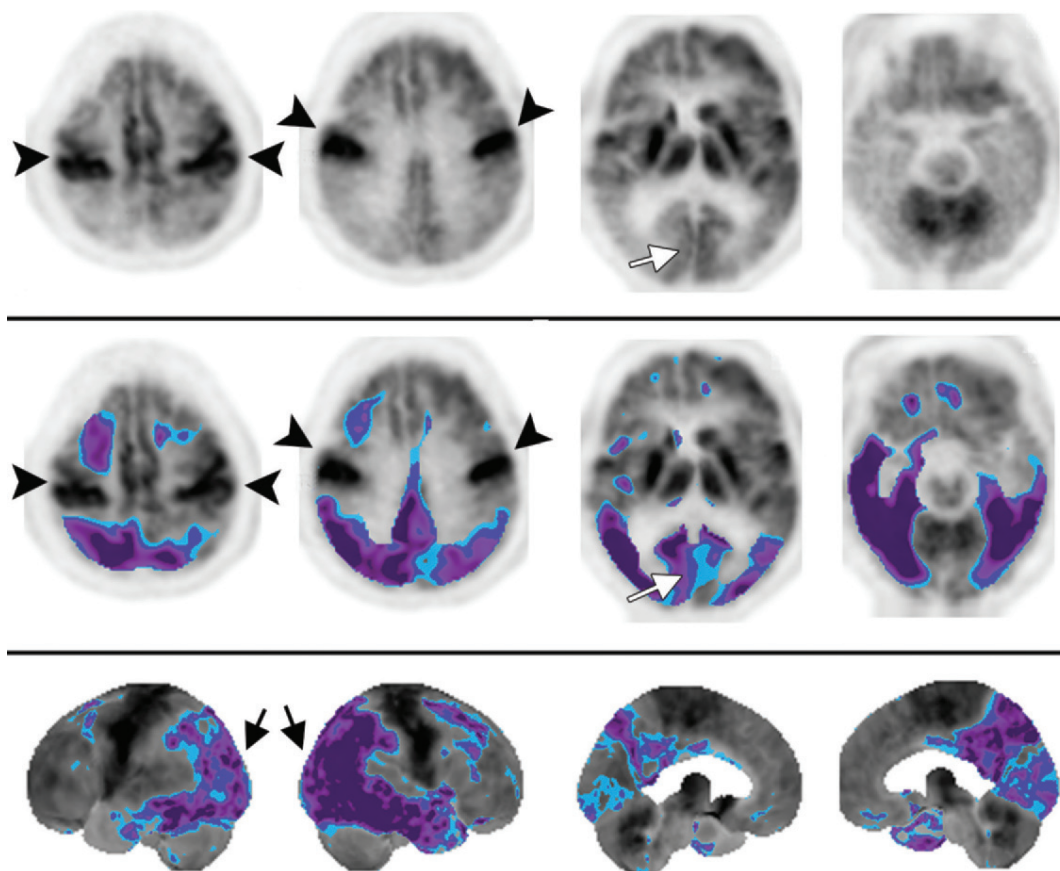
DLB. Axial gray-scale FDG PET images (top), corresponding statistical thresholding overlay images (middle), and 3D SSP images (bottom) (left to right: left lateral, right lateral, left medial, and right medial views) show severe bilateral prefrontal, parietal, temporal lobe, and posterior cingulate–precuneus cortical hypometabolism, findings that are typical of Alzheimer disease. However, there is additional hypometabolism in the occipital lobes, including the primary visual cortex (arrows), a finding that is diagnostic for DLB. Primary visual cortical hypometabolism is highly specific and moderately sensitive for distinguishing DLB from Alzheimer disease. In this case, preserved metabolism in the primary sensorimotor strip is relatively conspicuous (arrowheads) due to hypometabolism in both adjacent frontal and parietal association cortices. Note also the greater extent and intensity of hypometabolism throughout the involved regions of the right posterior parietotemporal cortices, a finding that can be seen in both DLB and Alzheimer disease. Blue = -2 SDs, purple = -3 SDs.
